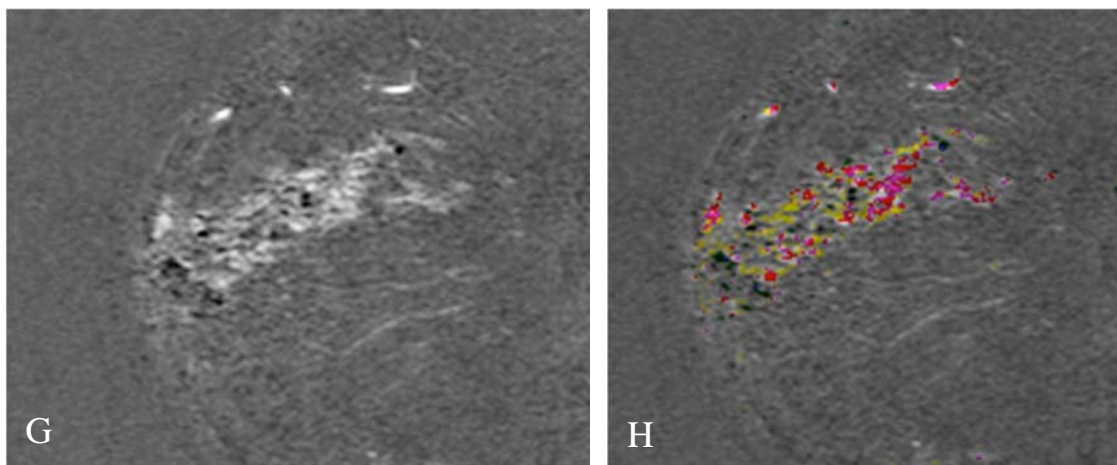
DCIS on MRI that was occult on mammography, ultrasound and ductography. The positive and negative scale subtraction reformatted oblique image (G) along the ductal ray shows dark dilated ducts that are etched in hyperintense signal. This appearance is typical of micropapillary DCIS. A mixture of persistent (yellow) and plateau (magenta) dynamics is depicted on computer aided detection (H). Pathology yielded multiple distended ducts filled with fluid and ductal carcinoma in situ present along the walls of the ducts.
